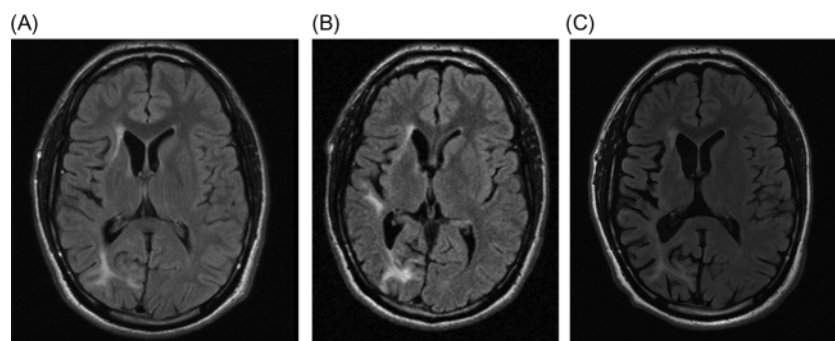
Axial fluid attenuated inversion recovery (FLAIR) MRI of brain from 2007 (A), 2009 (B) and 2012 (C) demonstrating variable right-sided hyper-intense signal change and progressive right hemiatrophy.
